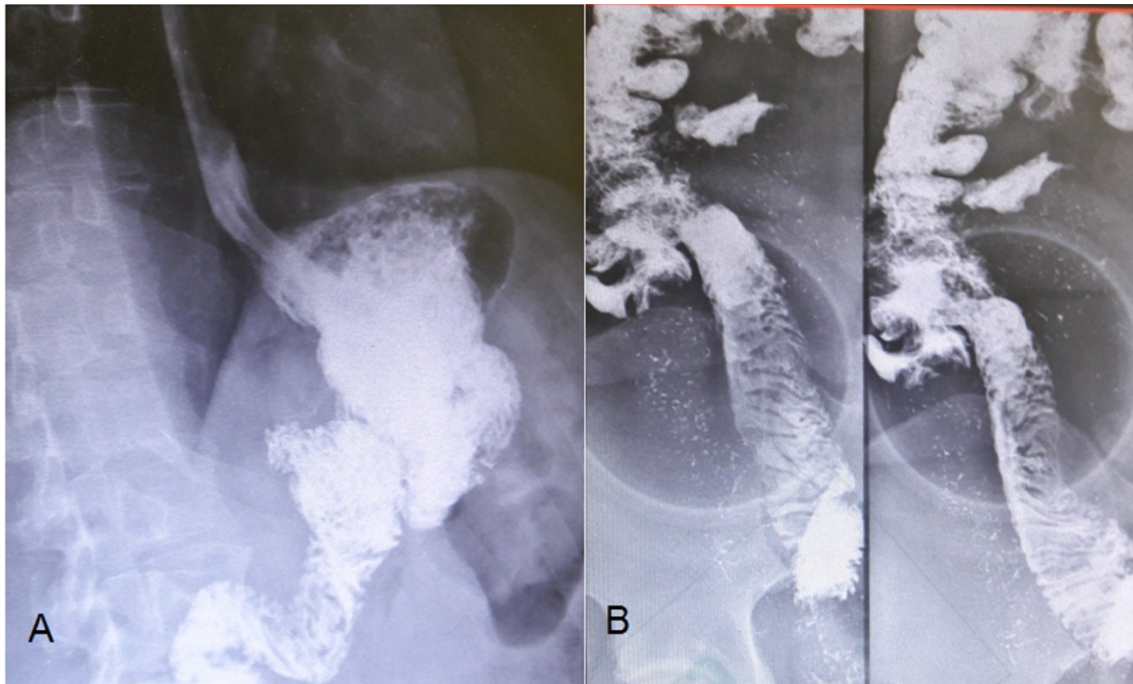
Contrasted gastrointestinal radiography series. A. Large gastric remnant with solid food residues. B: Thickening of the small bowel folds.
